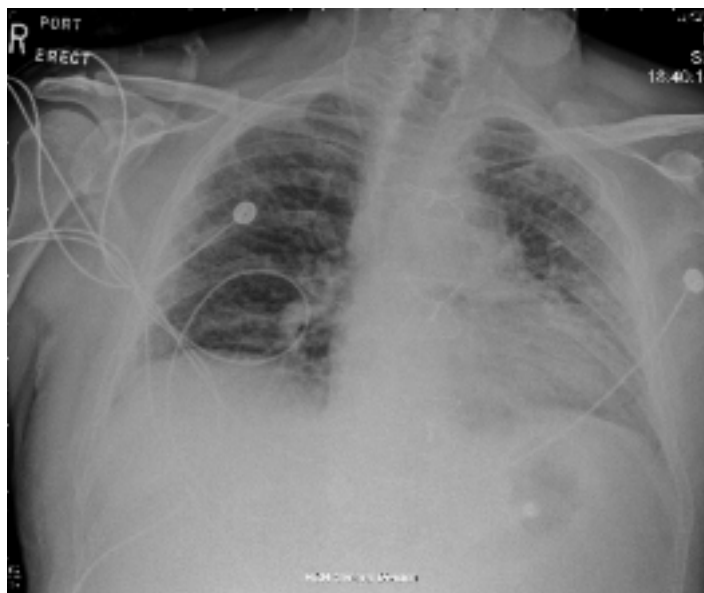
Chest radiograph taken 24 hours after admission showing bilateral interstitial reticular disease.
